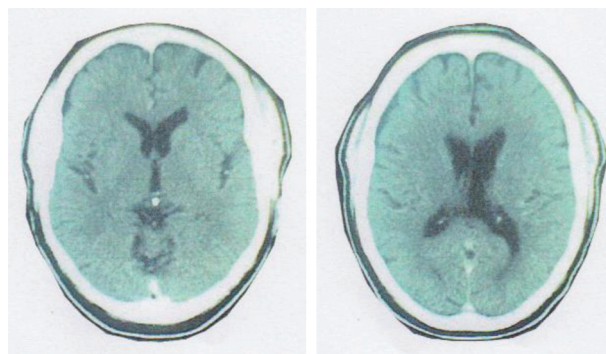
(left) shows pre-treatment CT Brain scan showing multiple ring-enhanced lesions suggestive of cerebral tuberculomas. Figure 1b (right) shows caseation in lesions in a magnified image of the CT Brain scan
